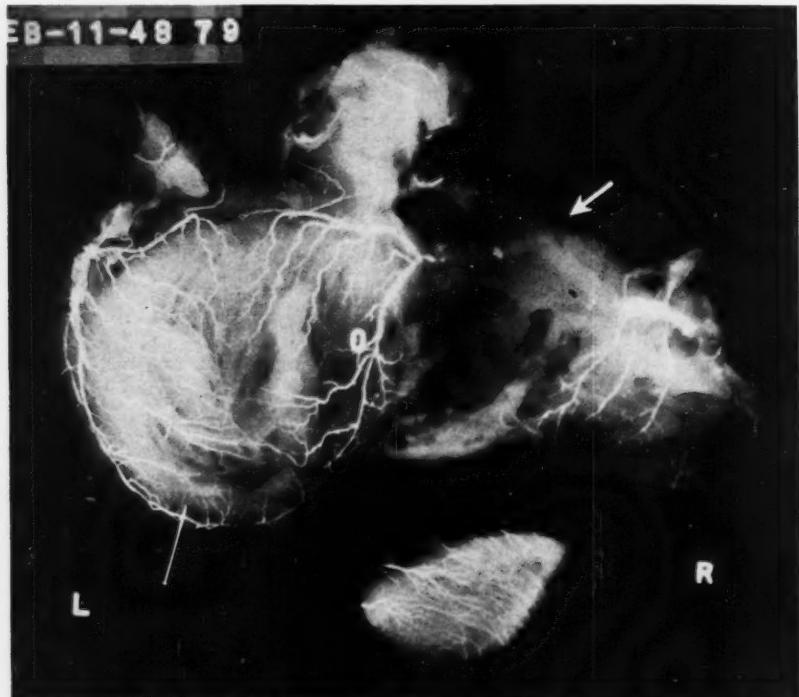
Roentgenogram of the heart of Patient 2 after injection of the coronary arteries with radio-opaque latex. An extensive thrombus occludes the lumen of the right coronary artery. (Appreciation is extended to Dr. Arthur Young for preparation of figure 3 and permission for its publication in this report.)
